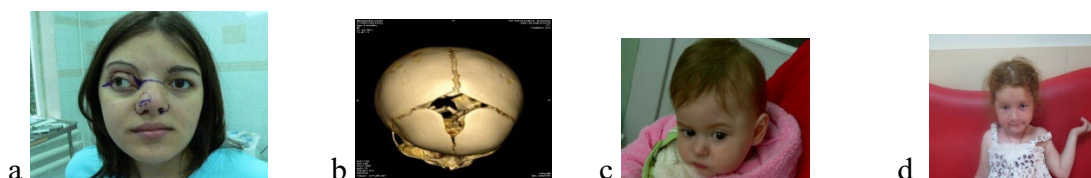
Unilateral coronary craniosynostosis: a - at the age of adolescence without surgical treatment; b - CT scan of the skull at this adolescence; c - unilateral craniosynostosis at the age of up to one year before treatment; d - unilateral craniosynostosis after surgical treatment
